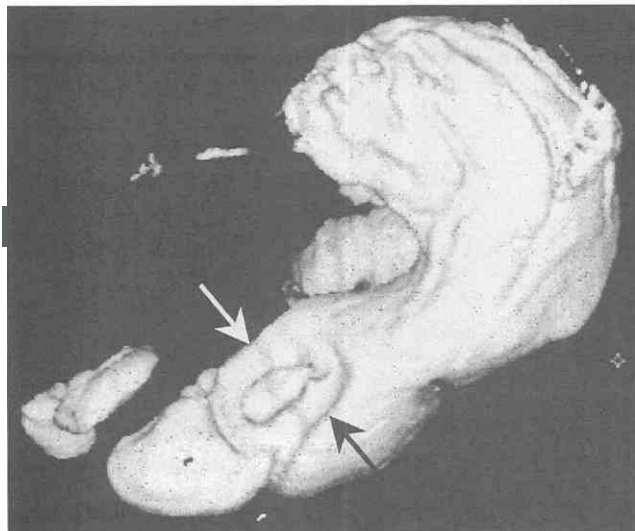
Three-dimensional spiral CT image of advanced ulcerofungating gastric cancer (arrows).
